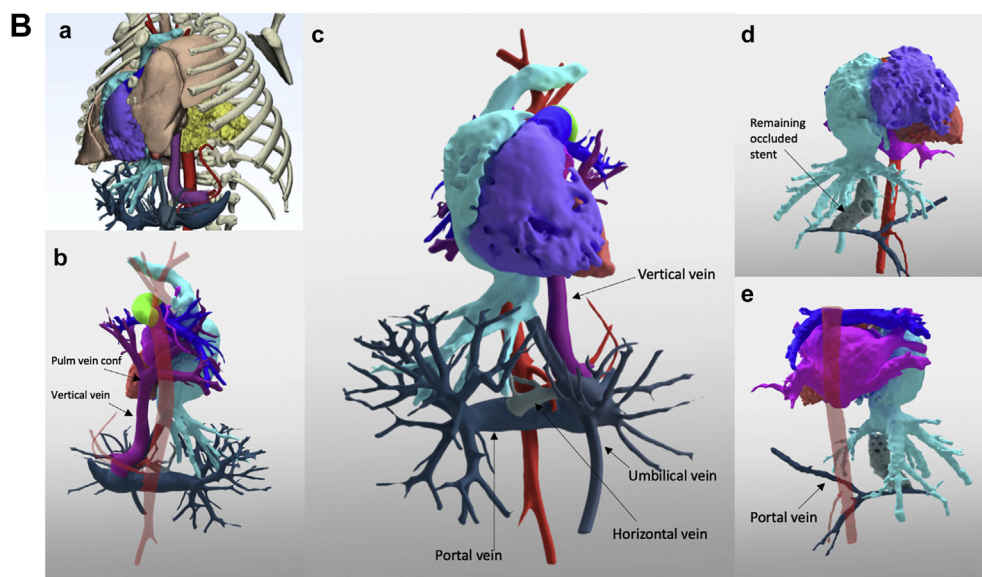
(A) Angiograms and fluoroscopy. (a) Overlaid computed tomography image to minimize contrast injections. (b) Wire through umbilical vein (green arrows) and through vertical vein during pulmonary vein angiogram. (c, d) 6 mm × 20 mm Formula 418 stent and overlying 7 mm × 20 mm Formula 418 stent in ductus venosus, 6 mm × 16 mm Formula 418 stent in hepatic portal vein egress; all ballooned to 12 atm (e-h) lateral view. Yellow arrows point to wire placement. (B) Three-dimensional segmentation and print. (a) Left diaphragmatic hernia. (b) Posterior view and (c) anterior view of total anomalous pulmonary venous return with vertical vein entering dilated portal venous system. (d) Anterior view and (e) posterior view on follow-up, showing residual occluded stent in the ductus venosus; note significant decrease in the size of the portal vein.
